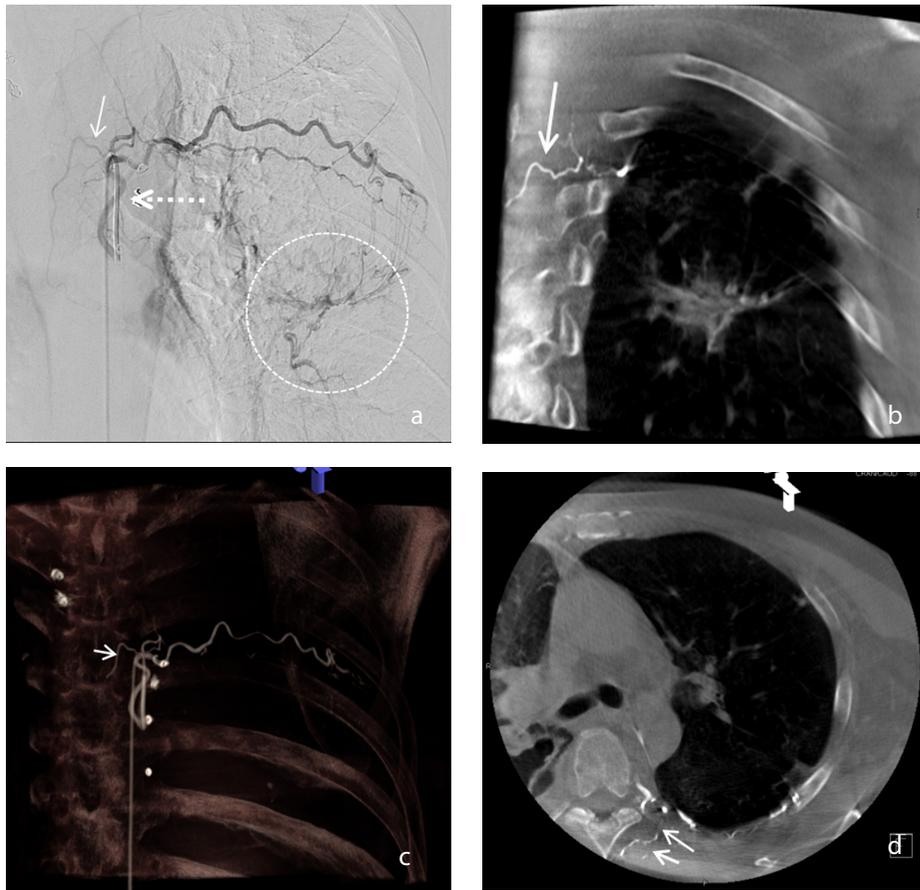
(a-d) Intraprocedural images of a 69-year-old male patient. Selective angiography (a) of the left seventh intercostal artery (ICA) (dotted arrow) demonstrated the ICA branching off an obscured hairpin-curved vessel (arrow) running towards the midline in the arterially enhanced phase. This obscured hairpin-curved vessel was determined by two interventional radiologists to be a possible artery of Adamkiewicz (AKA). The sign of systemic-to-pulmonary artery shunting (dotted circle) indicated the ICA was involved in bleeding. The corresponding contrast-enhanced oblique coronal cone-beam computed tomography (CT) image (b) and the three-dimensional volume-rendered image (c) from the contrast-enhanced cone-beam CT of the ICA clearly demonstrated the possible AKA (arrow) and the absence of the anterior spinal artery (ASA). The corresponding contrast-enhanced axial cone-beam CT image (d) of the right ICA demonstrated the absence of intradural enhancement, which indicated the absence of the ASA, and the possible AKA (arrow) running toward and terminating in the dorsal muscle and skin without entering the intervertebral foramen.
